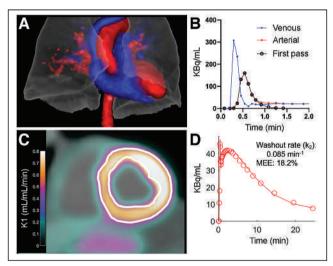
Automatic postprocessing of cardiac <sup>11</sup>C-acetate PET/CT images. (A) First-pass analysis after intravenous bolus injection of a few micrograms of <sup>11</sup>C-acetate. Arterial clusters (red) indicate left atrium, left ventricle, and aorta, whereas venous clusters (blue) indicate vena cava, right atrium, right ventricle, and pulmonary artery. (B) Time-activity curves of clusters for arterial and venous blood, and corresponding isolated first-pass peaks, from which cardiac output and external work (cardiac output  $\times$  mean arterial pressure) are calculated as in reference 11. (C) LV mass is measured by delineating LV endo- and epicardial contours by thresholding myocardium on parametric image representing myocardial blood flow (12). (D) Kinetics of radioactive content over time in myocardium is measured from region in C (8). 11C-acetate is trapped intracellularly as 11C-acetyl-coenzyme A and converted to <sup>11</sup>C-CO<sub>2</sub> by myocardial mitochondriae; washout rate of radioactivity is directly proportional to mean myocardial oxygen uptake. Total LV oxygen consumption is measured as mean myocardial oxygen uptake × LV mass. External work and total LV mean myocardial oxygen uptake are converted to Joules, the ratio of both yields MEE (8).
